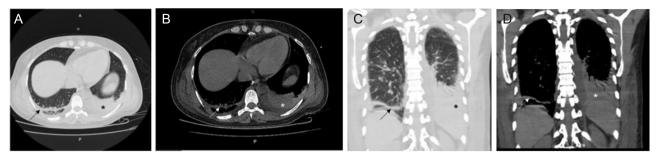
High-resolution computed tomography of the chest. (A-B) Axial section in the lung and mediastinum window shows the presence of atelectasis (arrow) and bibasal pleural effusion, predominantly left (asterisk) with concomitant consolidation. (C-D) Coronal slices using the lung and mediastinum window with the findings referenced in A and B. Source: Authors.
